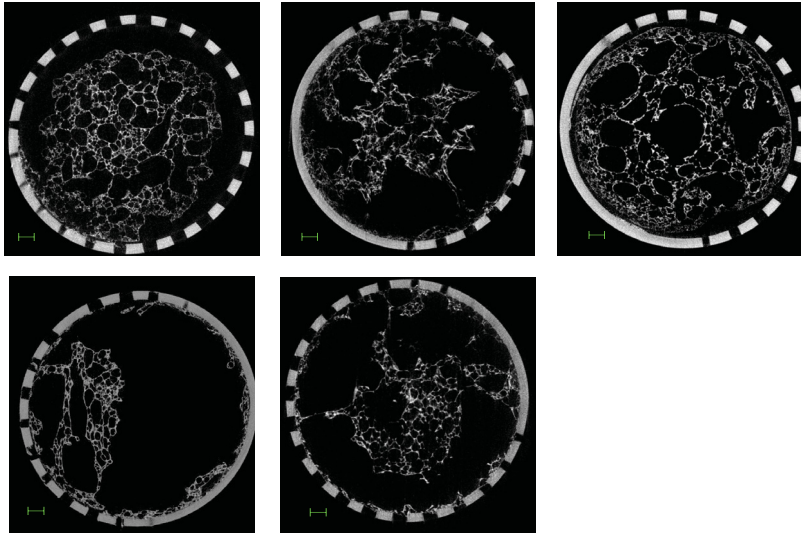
X-ray μ -CT images of DF with PWC 25% (N2 (top left), N6 (top middle), N8 (top right), N10 (bottom left) and N14 (bottom middle). Scale indicated in green equals 1 mm.
